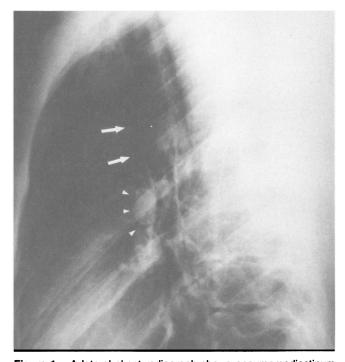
A lateral chest radiograph shows pneumomediastinum with air lucency in the pretracheal space (arrows) and surrounding the right pulmonary artery (arrowheads).
